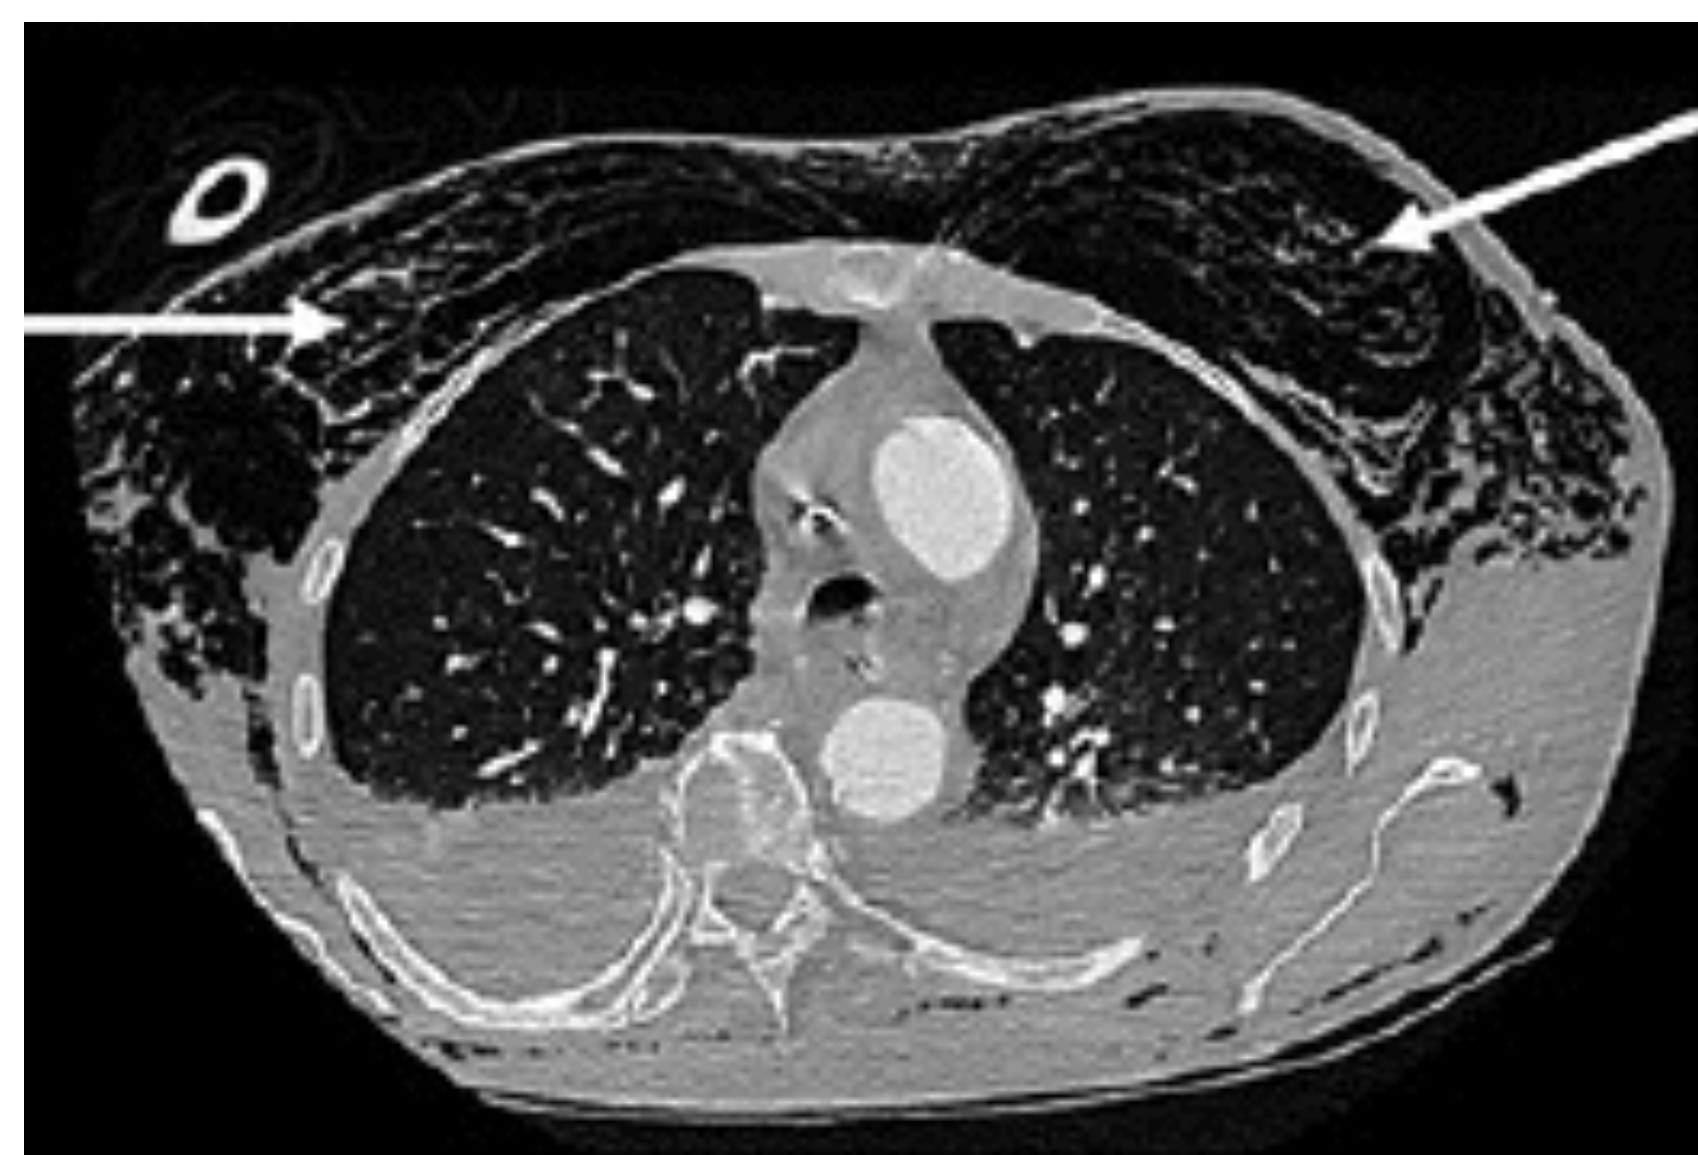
Coronal chest CT demonstrating subcutaneous emphysema in thorax. (Diop, Giabicani, & Legriel, 2021, p. 107)
